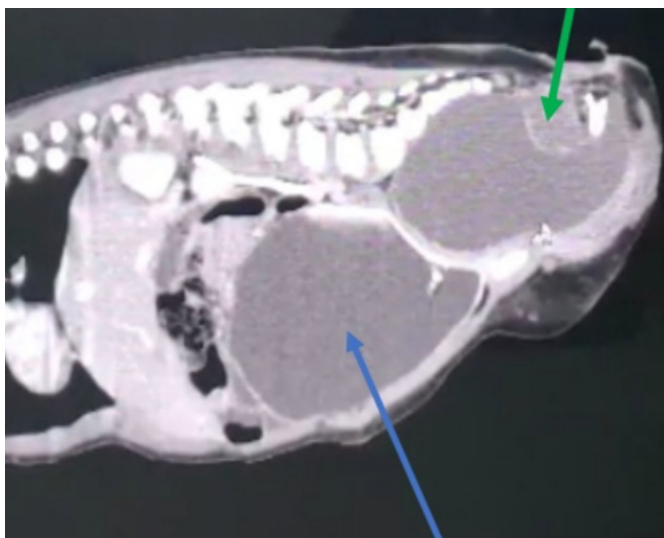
CT scan after 2 months of chemotherapy
